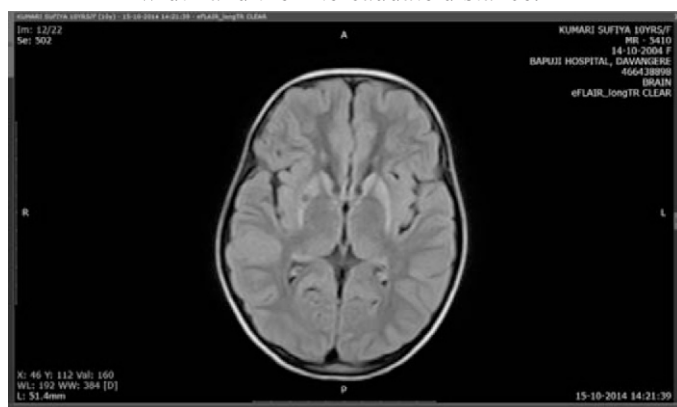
FLAIR Axial section of the brain shows a small cystic change within the right lentiform nucleus.
